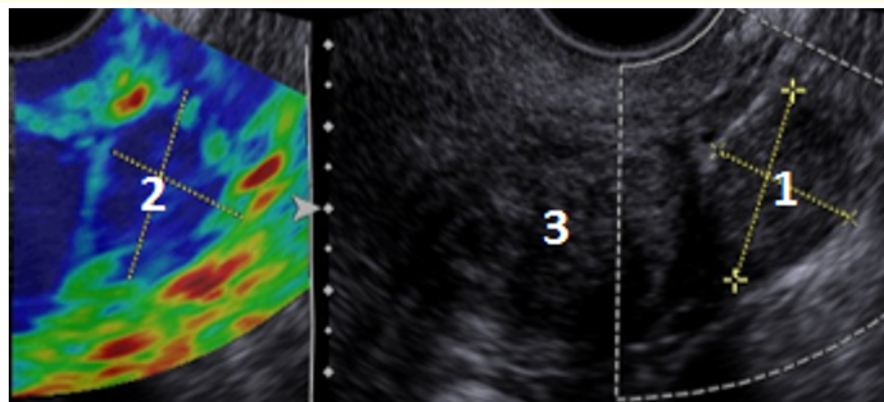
Ultrasound tomogram of metastatic ovarian tumor patient L with diagnosis of low-differentiated endometrial adenocarcinoma: 1- to the left of the uterus a solid metastatic tumor; 2- compression elastography mode - structures of high rigidity; 3- myometry.
